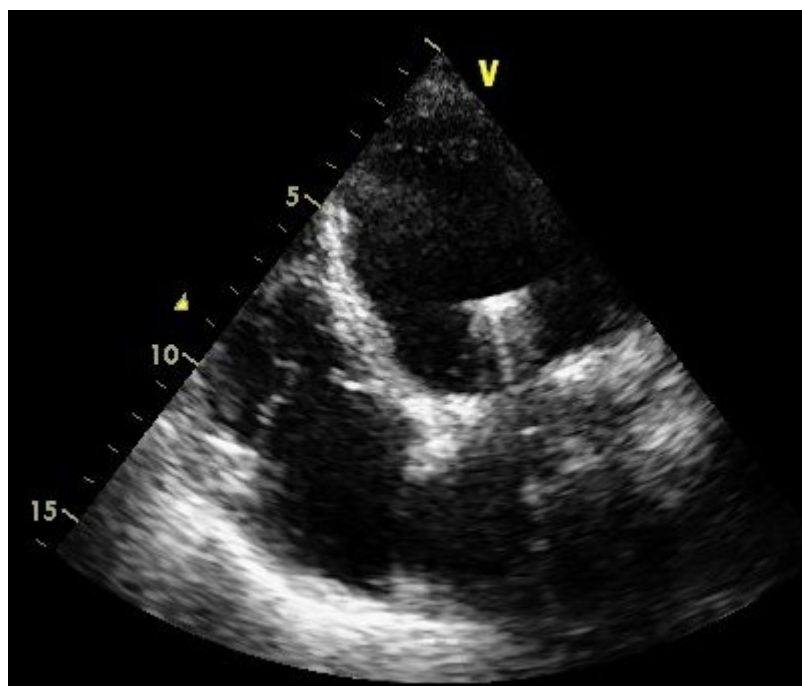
Echocardiogram after treatment - no vegetation seen
